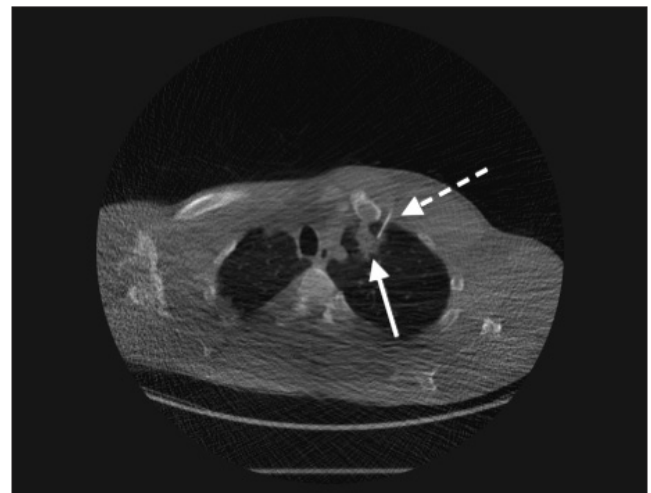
Axial CT imaging of the thorax demonstrating the tip of the transthoracic biopsy needle (broken arrow) entering a lesion in the left upper lobe (solid arrow).
